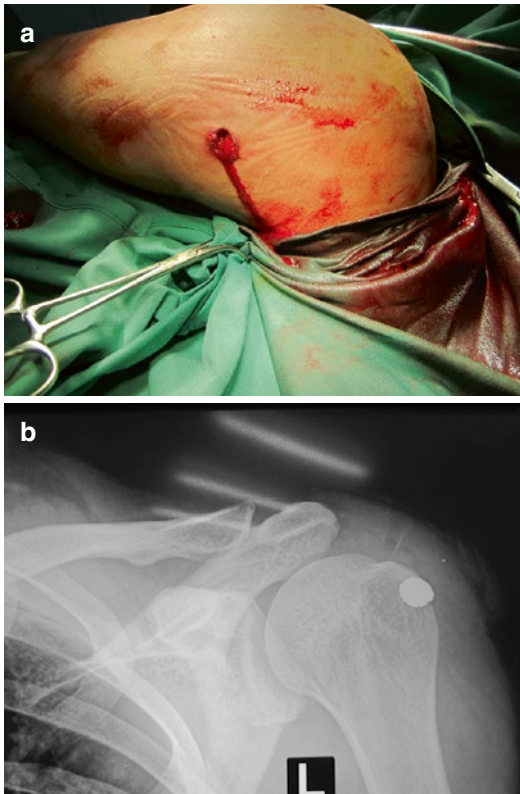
(a) X-ray of low velocity bullet lodged adjacent to proximal humerus and (b) clinical picture. You can appreciate the entry wound
